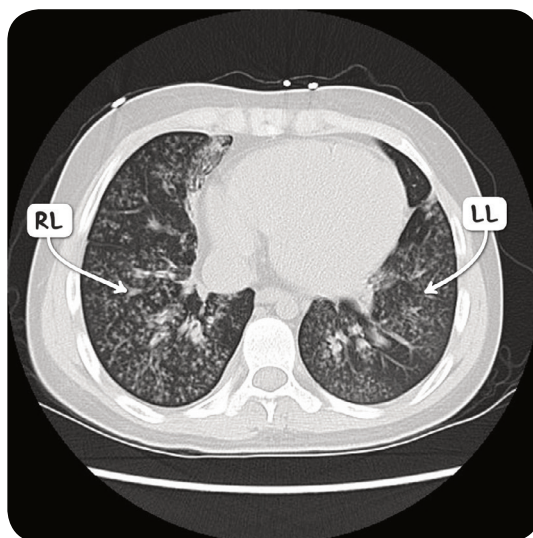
A CT scan of the chest in the axial plane in an individual with severe bronchiolitis. Both lung fields demonstrate the tree-in-bud pattern.
